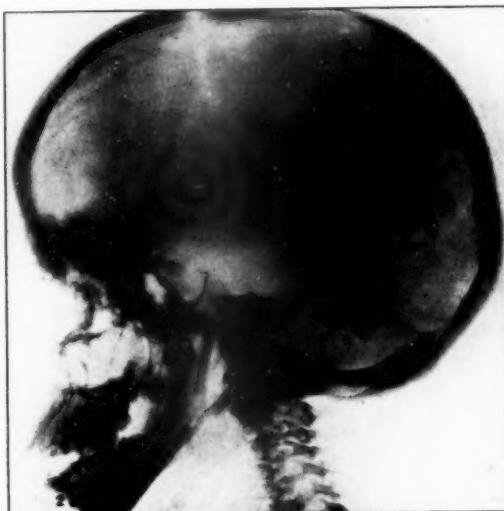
X-ray of skull (20.5.52).
